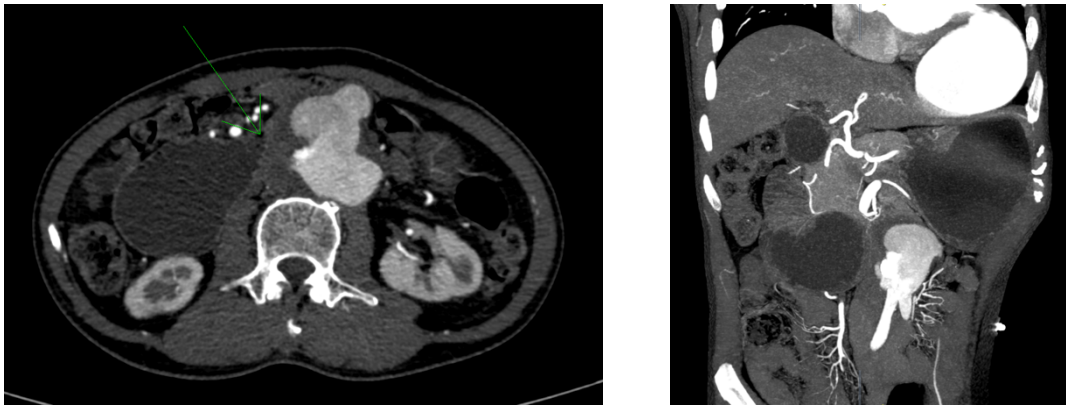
Computed tomography angiogram showing a multilobulated infrarenal aortic dilatation measuring 6.7 x 6.8 x 6.7 cm.
